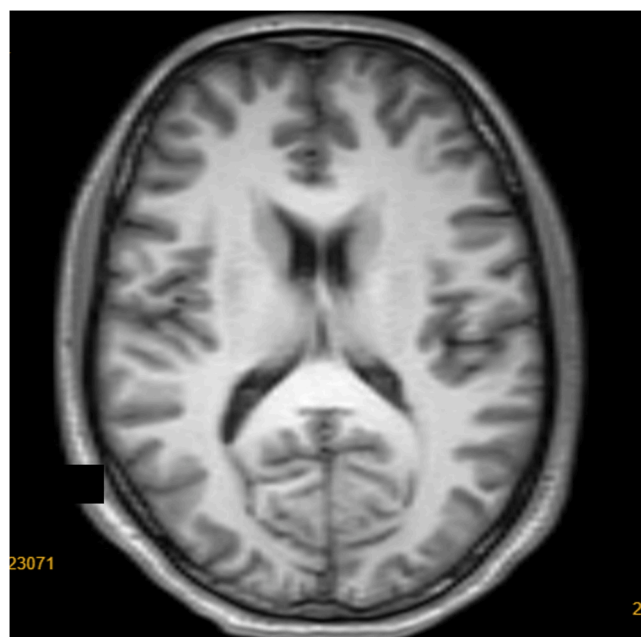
Normal brain MRI.
